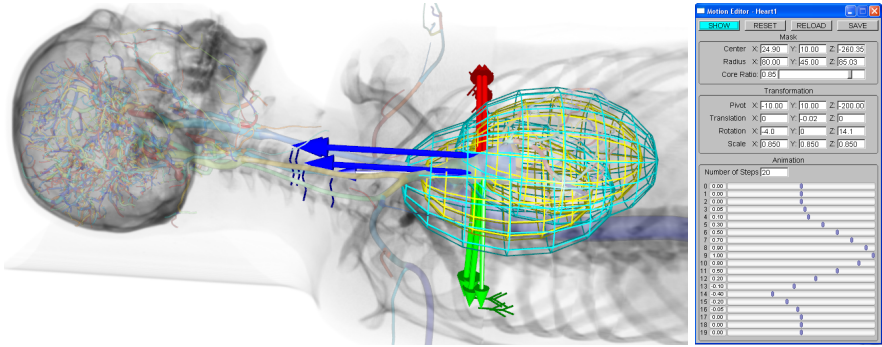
Left:* X-Ray rendering under deformation. *Right:* Interactive motion editor.
